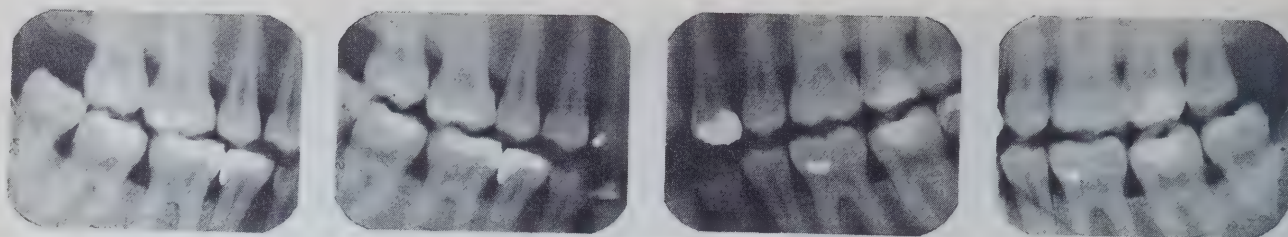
Bite-wing radiographs (August 1969).
